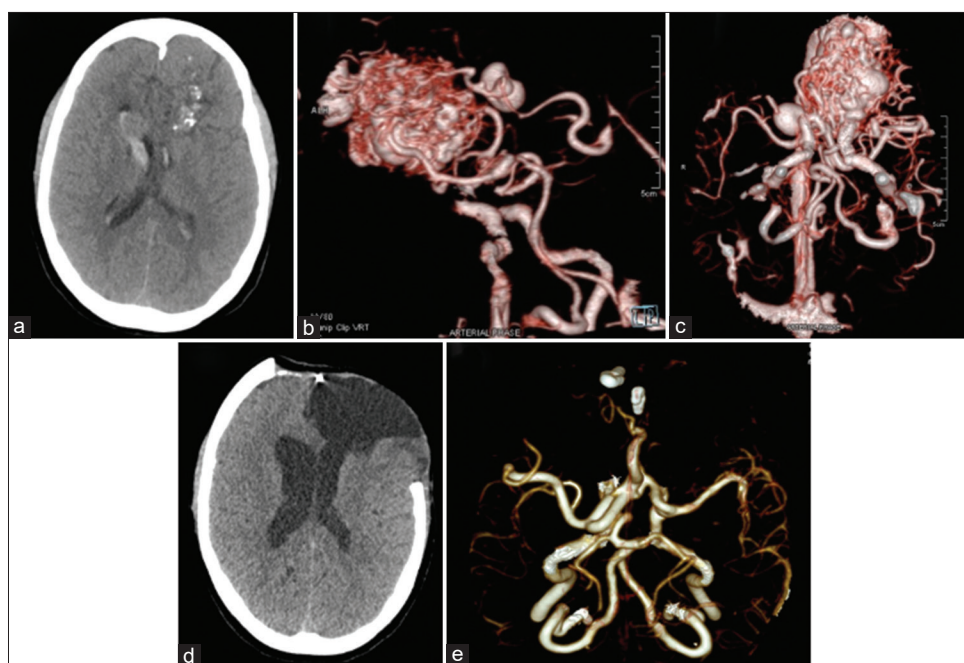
Left frontal arteriovenous malformation of SMG V and supplemented SMG 7. (a) Plain computed tomography scan showing evidence of calcified lesion on left frontal lobe with hyper-density in ventricle showing intraventricular hemorrhage. (b) Three-dimensional reconstruction of computed tomography angiogram sagittal view with intravenous contrast showing large left frontal arteriovenous malformation with feeders from left Middle cerebral artery, anterior cerebral artery, internal carotid artery and draining into vein of Galen to straight sinus. (c) Three-dimensional reconstruction of computed tomography angiogram axial view with intravenous contrast showing larger left frontal arteriovenous malformation. (d) Postoperative plain computed tomography scan showing complete excision of left frontal arteriovenous malformation with cranial defect over left fronto-temporal and part of right frontal bone. (e) Postoperative three-dimensional reconstruction of computed tomography angiogram axial view with intravenous contrast showing complete excision of arteriovenous malformation with normal cerebral vessels and two aneurysm clips in anterior circulation
